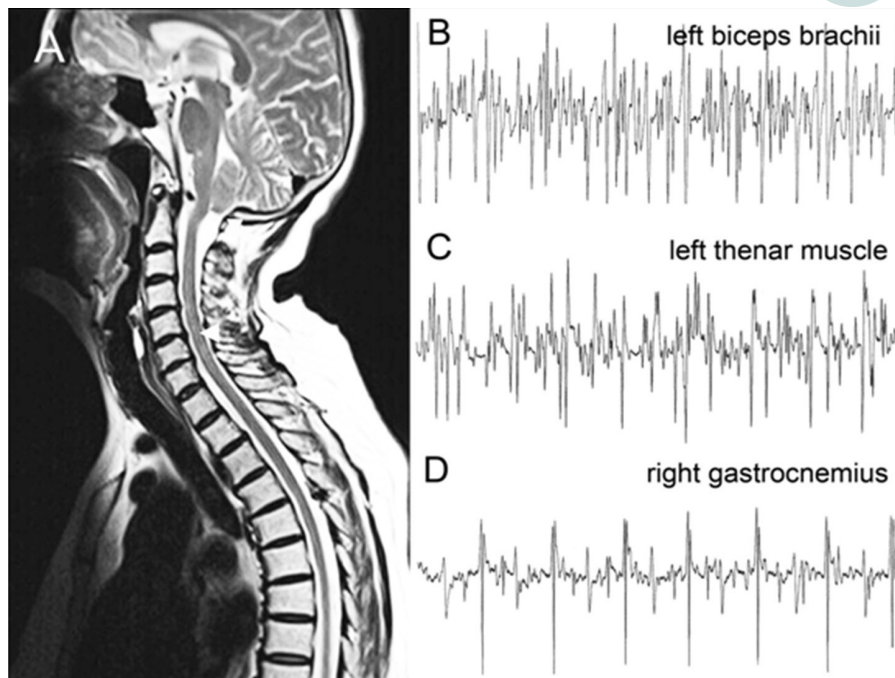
Brain and spine image and electromyography of the ALS case. (A) Brain MRI suggests Arnold-Chiari malformation type I (arrow). Spine MRI reveals slight prominence of intervertebral disks at C4/5, C6/7 and L4/5-L5/S1, and no abnormality was observed in the whole spinal cord. (B-D) Electromyography showed denervation potentials in the left biceps brachii (B), the left thenar muscle (C) and right gastrocnemius (D). ALS: amyotrophic lateral sclerosis; MRI: magnetic resonance imaging
